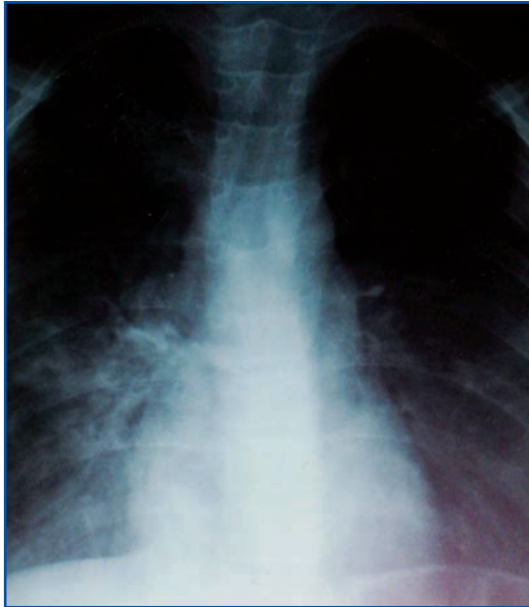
Anterior chest X-ray.
